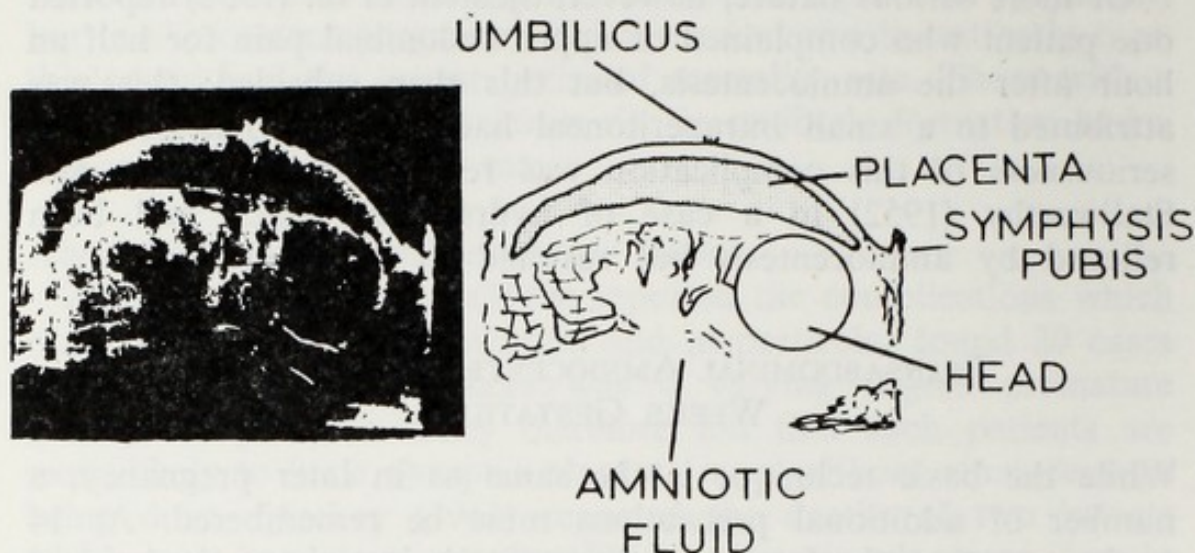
Ultrasonogram showing an anterior placenta.
